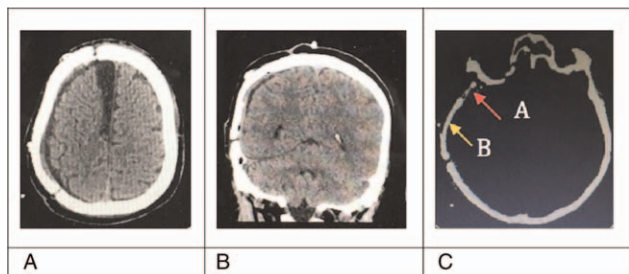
Computed tomography scan showing that the hybrid implant (A, PMMA; B, autologous bone flap) was well aligned to adjacent skull edges.
